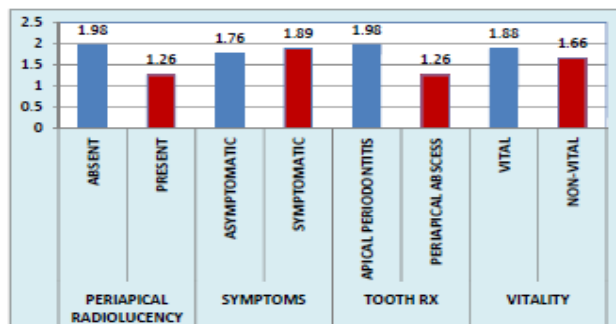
Graphical Presentation Of Comparison Of Post Endodontic Pain In Cases With Type Of Radiographic And Clinical Findings
